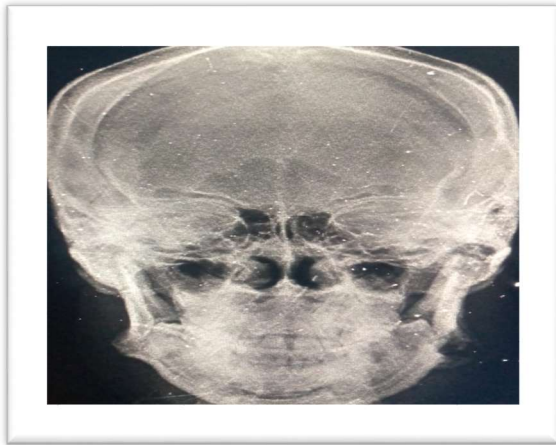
Plain radiography of the jaws showing left multiple radiolucency in the mandible caused by osteomyelitis.
